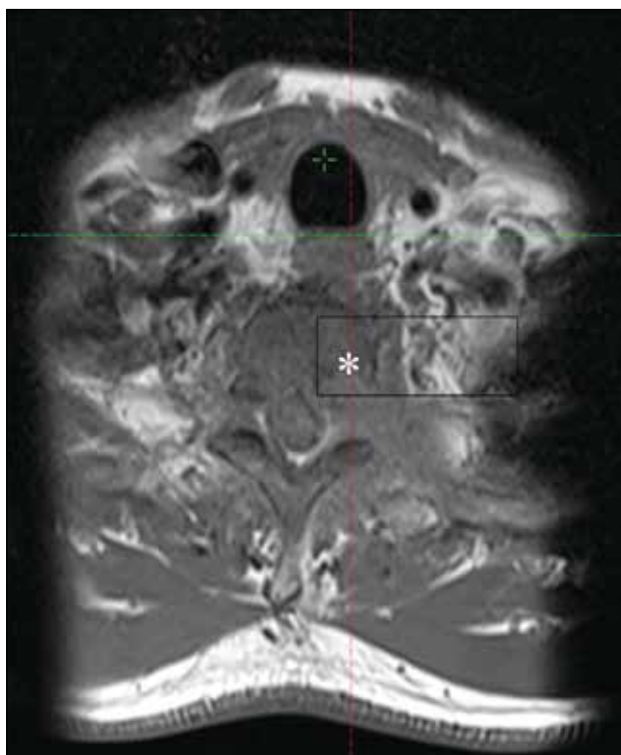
C6 bone metastases (asterisk) on T1-weighted magnetic resonance imaging.
